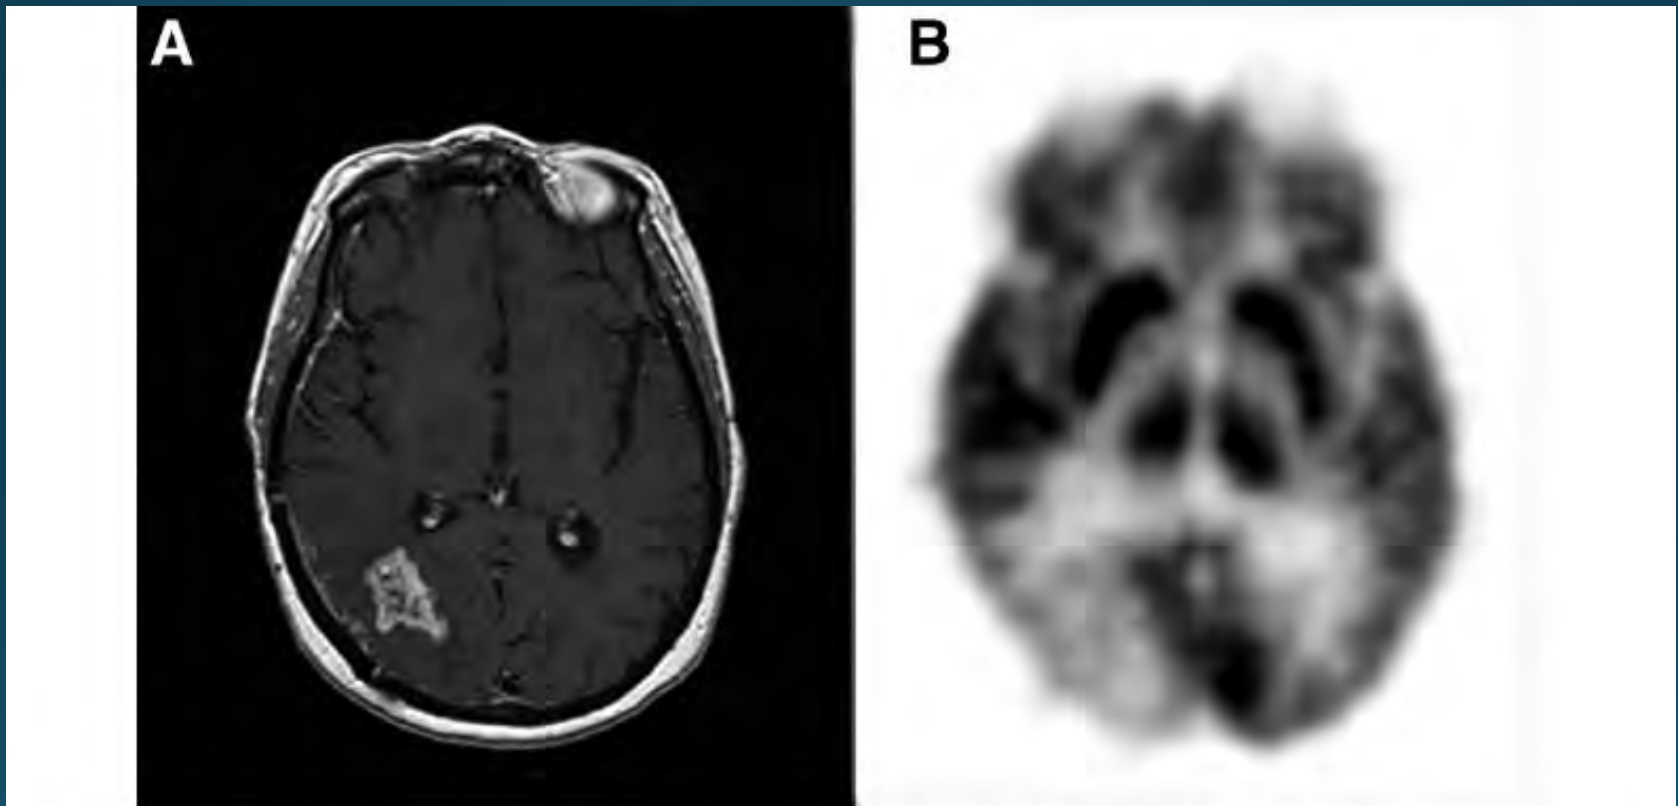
Image coregistration of FDG-PET and MRI. Shown are (A) MRI and (B) FDG-PET images from a 59-year-old woman with recurrent right parieto-occipital glioblastoma. MRI shows a contrast enhancing lesion that is slightly increased compared with the previous study. FDG-PET showed moderate uptake lower than the normal gray matter, but greater than the expected background of the adjacent brain tissue and corresponded to the abnormal contrast enhancing region on MRI. Surgery demonstrated recurrent glioblastoma.
